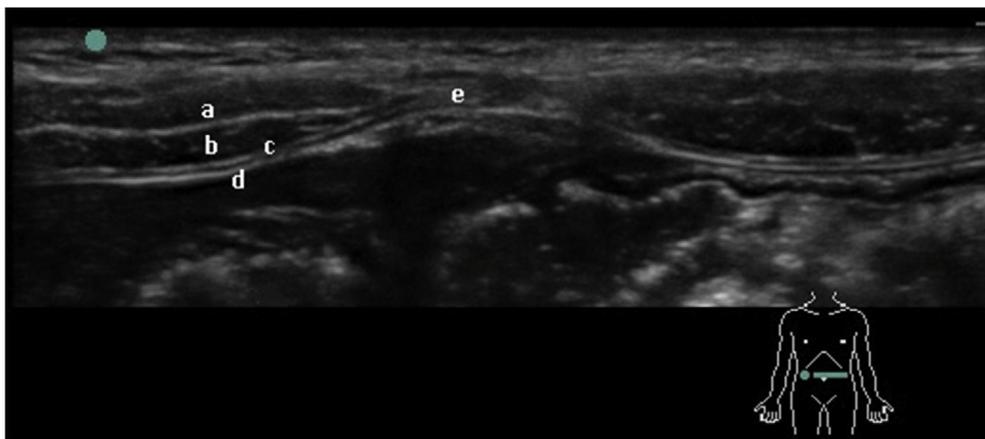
Ultrasound-guided rectus sheath block (depth 1.5 cm). (a) Anterior rectus sheath; (b) rectus muscle; (c) posterior rectus sheath; (d) peritoneum; (e) linea alba.
